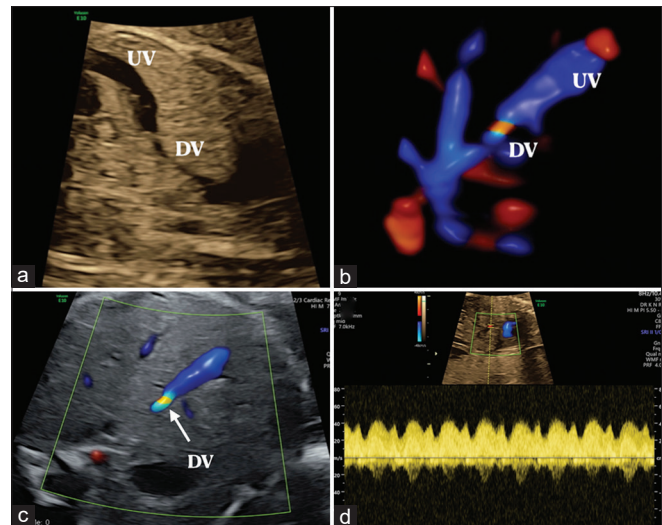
(a) Normal intra-abdominal umbilical vein and ductus venosus (DV) opening into portohepatic system, (b) color flow rendered image showing increased flow velocity at DV, (c) Abdominal cross section at the level of DV, (d) Spectral Doppler of DV showing the typical pattern with absent “a” reversal, DV: ductus venosus, UV: umbilical vein, IVC: Inferior vena cava
